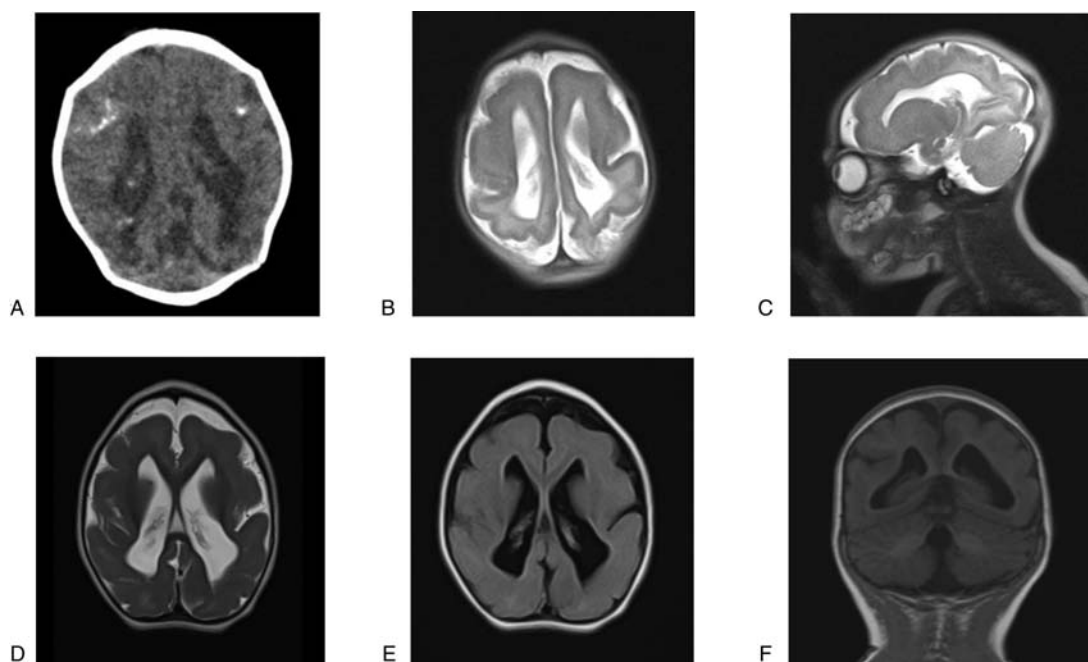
Axial CT (A), axial (B), and sagittal (C) T2-weighted MR images showing microcephaly and skull collapse. There is moderate ventricular dilatation, enlargement of extra-axial cerebrospinal fluid spaces and thinning of brain parenchyma. The gyral pattern is abnormally smooth for gestational age. Subcortical calcifications are predominantly located in the frontal lobes. Axial (D) and (E) T2-weighted, and coronal (F) T1-weighted follow-up MR images registered at 16-month-old showing the same pattern observed at birth.
